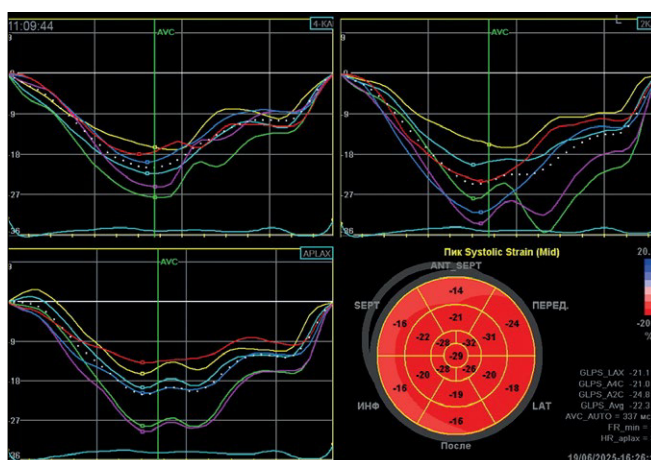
Results of measuring the longitudinal systolic strain of the left ventricle using the speckle-tracking echocardiography method. Graphs of strain changes throughout the cardiac cycle in all 17 segments of the left ventricle are presented. Strain values at the moment of aortic valve closure are shown on the color map.
